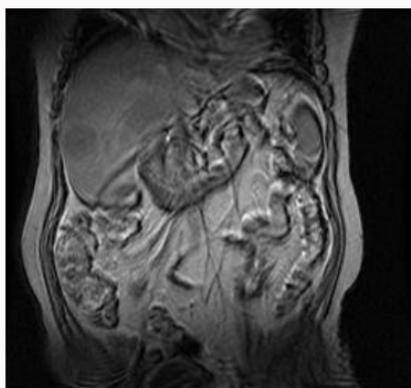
Frontal view of abdominal MRI.
